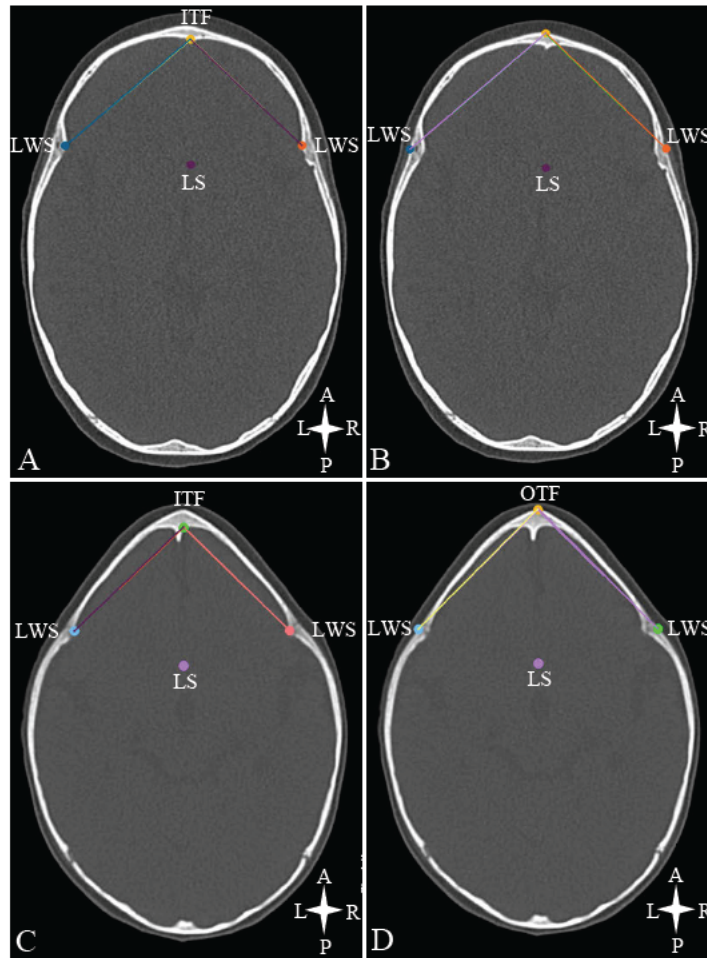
Metopic indices of the ACF on an axial CT scan of a normal patient (A and B) and a trigonocephaly patient (C and D) (EBA: vertex at ITF and terminal points at LWS; FA: vertex at OTF and terminal points at LWS). Key: ITF – inner table of frontal bone; OTF – outer table of frontal bone; LWS – lesser wings of sphenoid bone; LS – midpoint of limbus sphenoidale (transcended landmark used as a reference plane)
